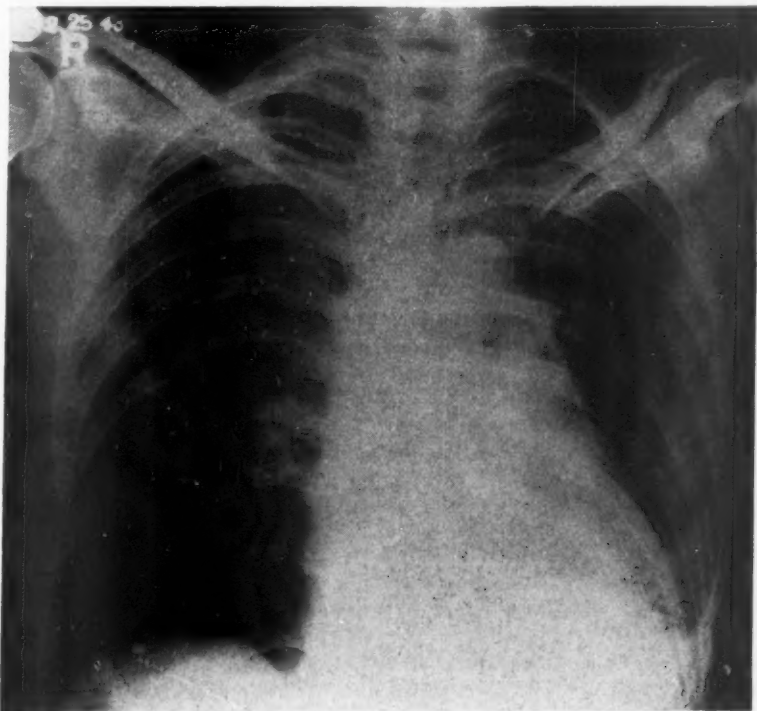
Roentgenogram of chest taken February 25, 1943 (twenty-four hours later). Note the marked reduction in the total size of the heart shadow, and especially the disappearance of the right auricular shadow behind the sternum.
